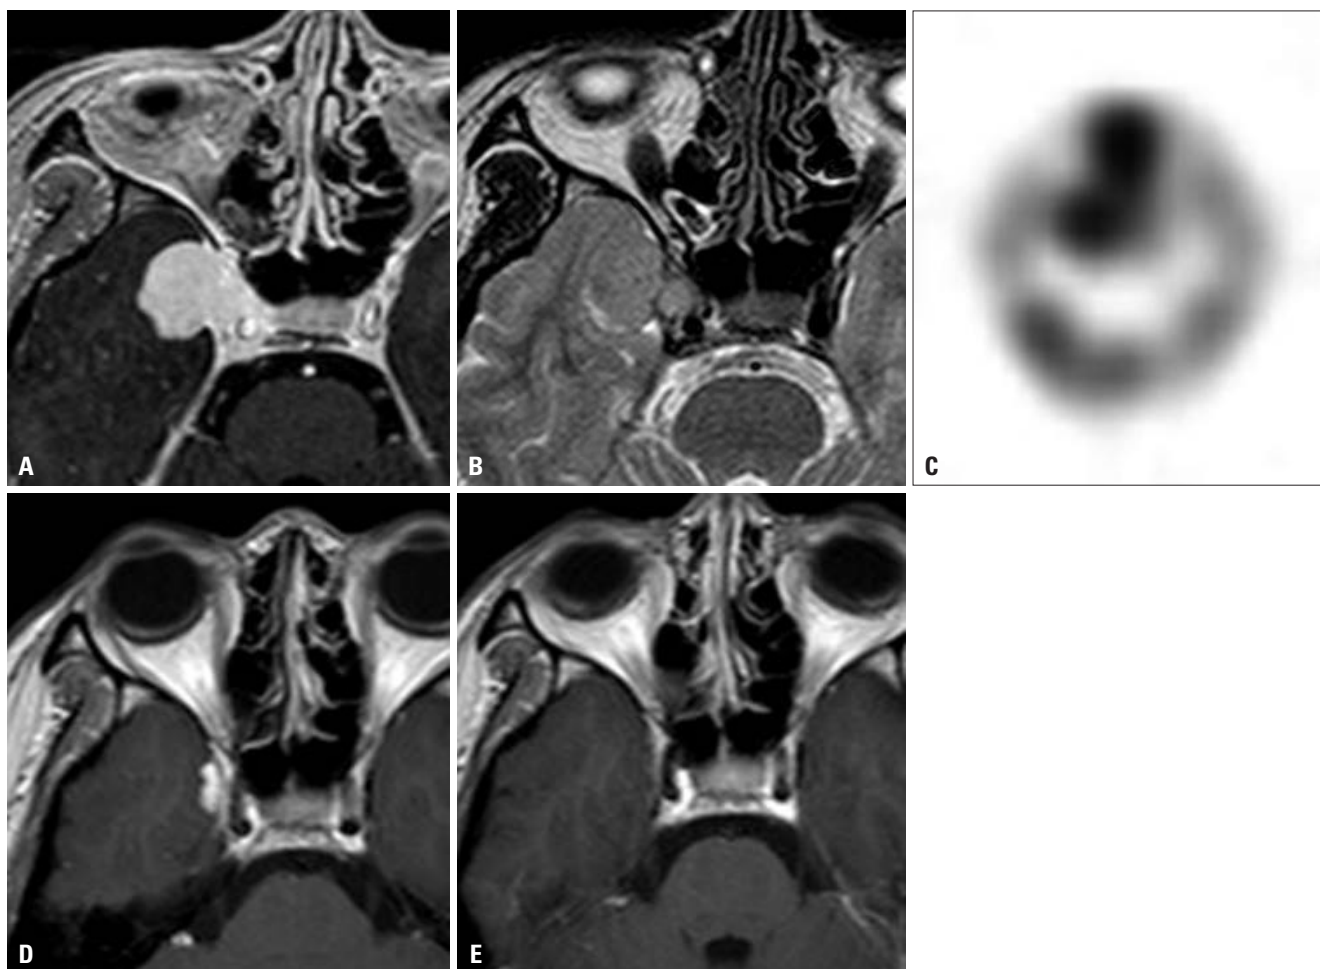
A 35-year-old female patient presented with incomplete right 6th cranial nerve palsy. T1-weighted (A) and T2-weighted images (B) showed a mass at the right cavernous sinus. Red blood cell scintigraphy (C) showed marked radioisotope uptake at the lesion, confirming the diagnosis of cavernous sinus cavernous hemangioma. The measured volume was 5.3 mL. After GKS (14 Gy of marginal dose at the 50% isodose line), all symptoms were resolved within 1 week. The 6-month follow-up magnetic resonance image showed remarkable decrease of the lesion (D), while the lesion could be hardly seen at 35 months after GKS (E). GKS, Gamma Knife surgery.
